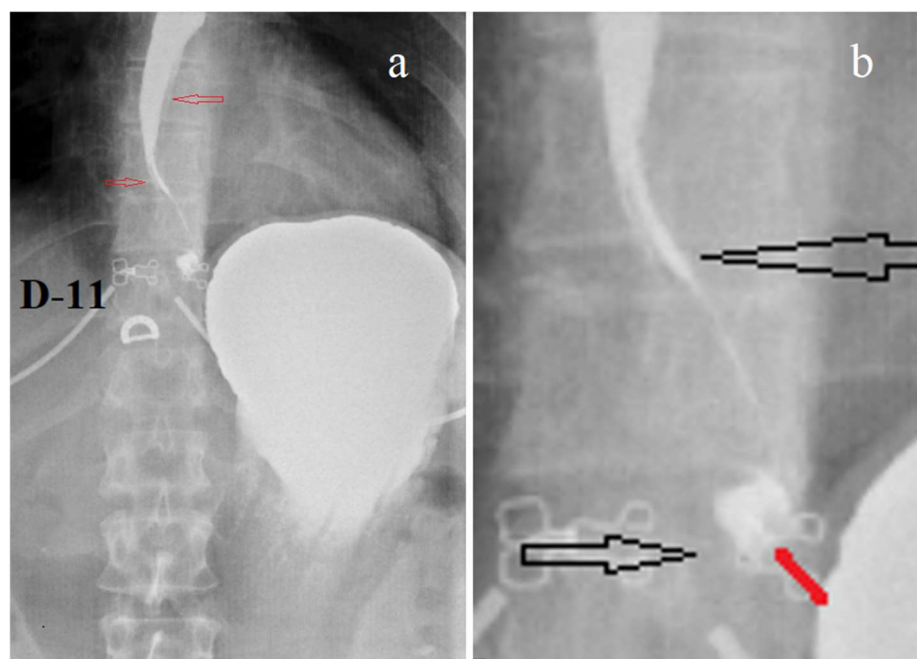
Radiograph of the esophagus and EGJ, performed during high pressure in the stomach (a). Scheme to it (b). The maximum width of the esophagus is within
